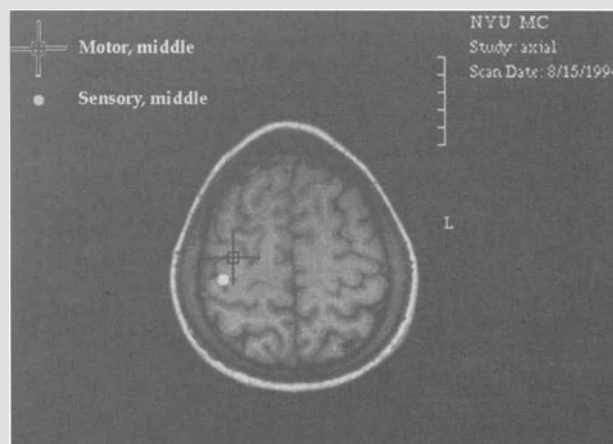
Normative MEG data: MEG localization of sensorimotor cortex in a normal (28 year old right-handed female) adult. Sensory and motor evoked magnetic fields were recorded in response to tactile stimulation of and motor activity of the left middle finger, respectively. The equivalent magnetic source dipoles were mapped onto MRI scans. These dipoles localise the precentral motor cortex, the postcentral sensory cortex and the central sulcus
